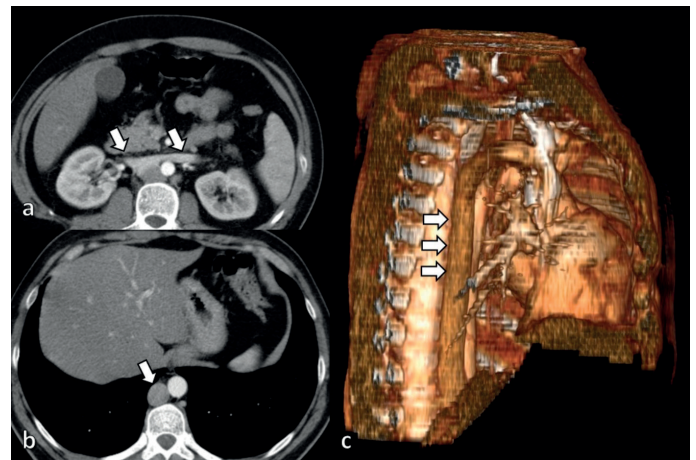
In another case additionally absence of the intrahepatic IVC is present too. (a) On axial CT image, blood in renal veins return in the azygos system directly (white arrows). On axial CT image (b) and 3D reformat image (c) you can see enlarged azygos vein (white arrows).
